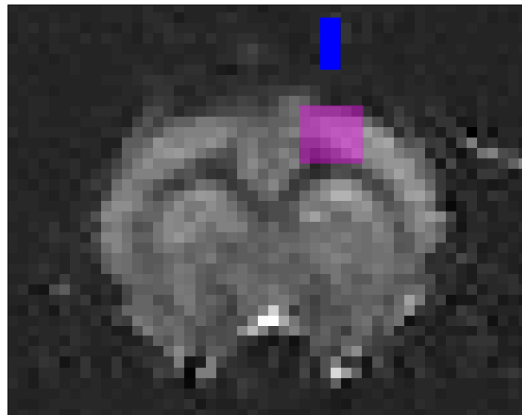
ASL slice showing optical fiber locations (blue) and region-of-interest for averaging of MRI CBF (magenta)
